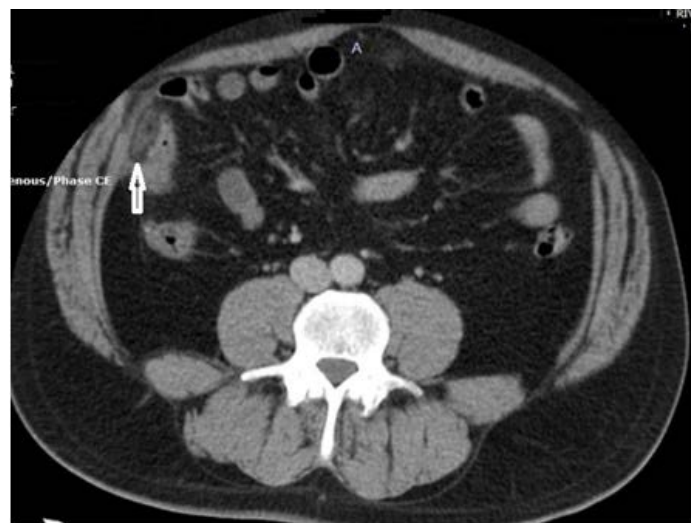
CT images of the mass for case-1
